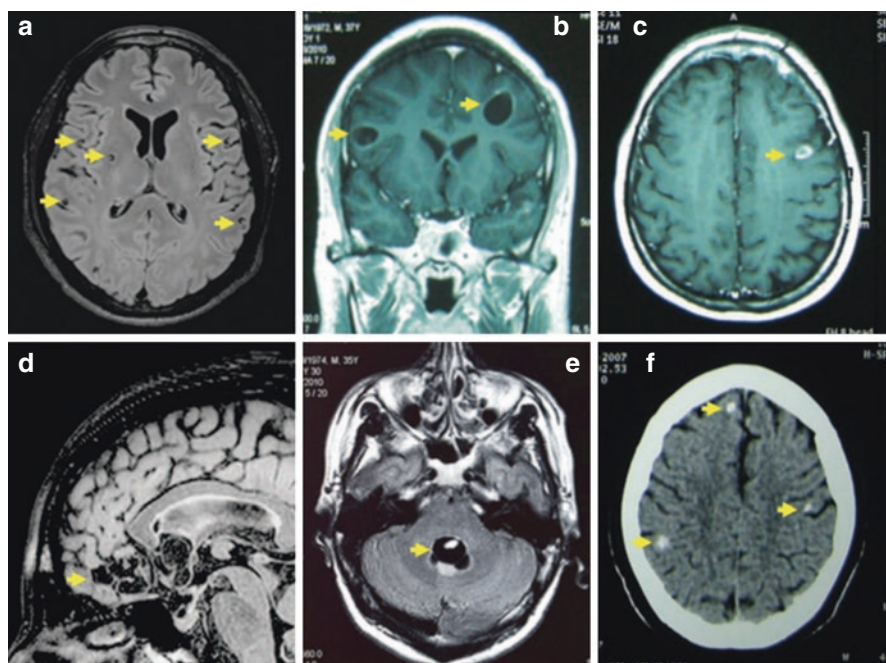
(a–f) Stages of human neurocysticercosis. (a) FLAIR MRI sequence T1, showing Parenchymal viable cysts. (c) post contrast T1 MRI sequence, single enhancing lesion extensive basal. (d), FLAIR MRI sequence with subarachnoid neurocysticercosis in the anterior fossa. (e), FLAIR MRI sequence, viable cyst in the IV and intraparenchymal brain calcifications. FLAIR fluid-attenuated inversion recovery. (From White and Garcia [44], with permission)
